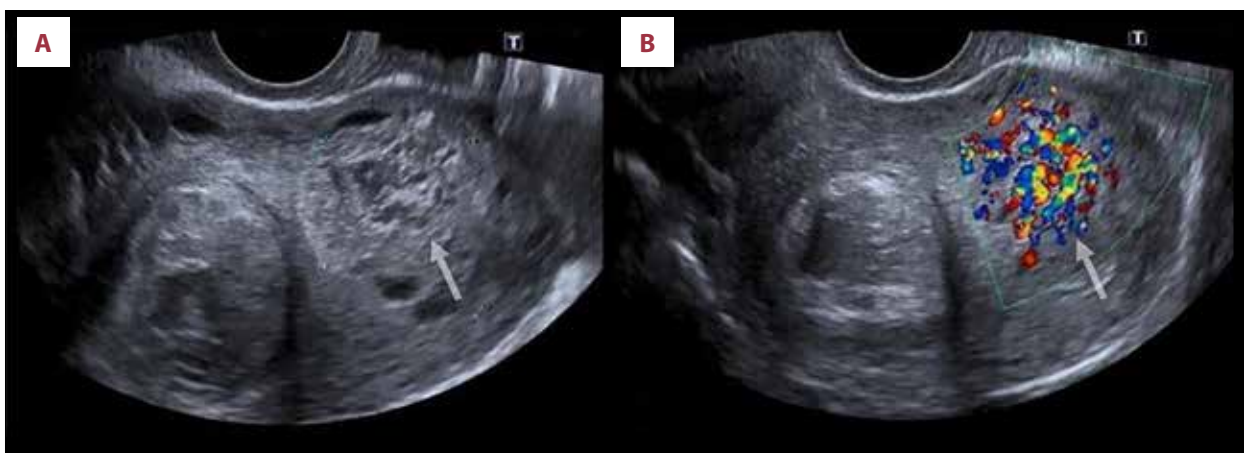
Transvaginal sonography without (A) and with (B) color Doppler imaging. A complex intrauterine lesion that spread through the myometrium (arrow) with color Doppler score 4. A fibroma was also detected near this hypervascular lesion.
